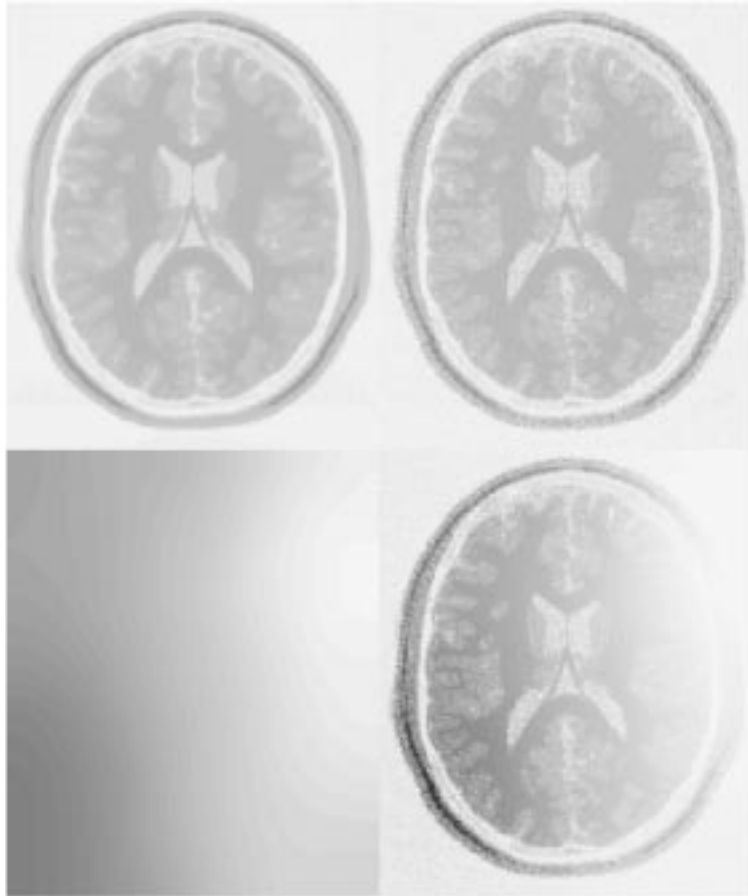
The MR images are modelled as a number of distinct clusters (top left), with different levels of Gaussian random noise added to each cluster (top right). The intensity modulation is assumed to be smoothly varying (bottom left), and is applied as a straightforward multiplication of the modulation field with the image (bottom right).
